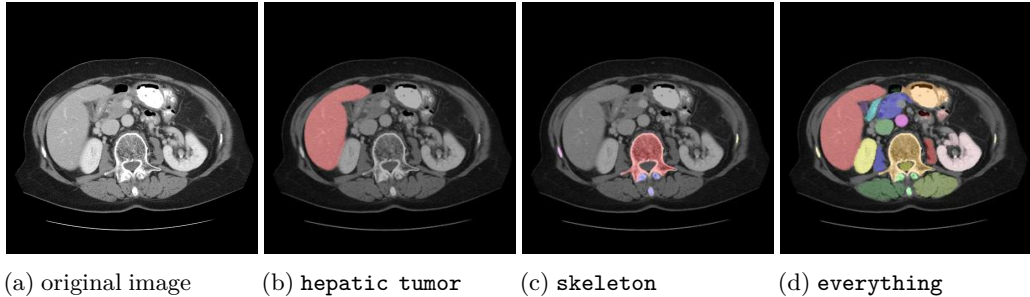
(a) The original CT image slice. (b-d) The selected argument by VILA-M3 to the VISTA3D expert model call.
